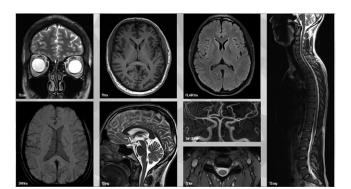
MRI cerebrospinal sequences in the 3-Tesla protocol.
